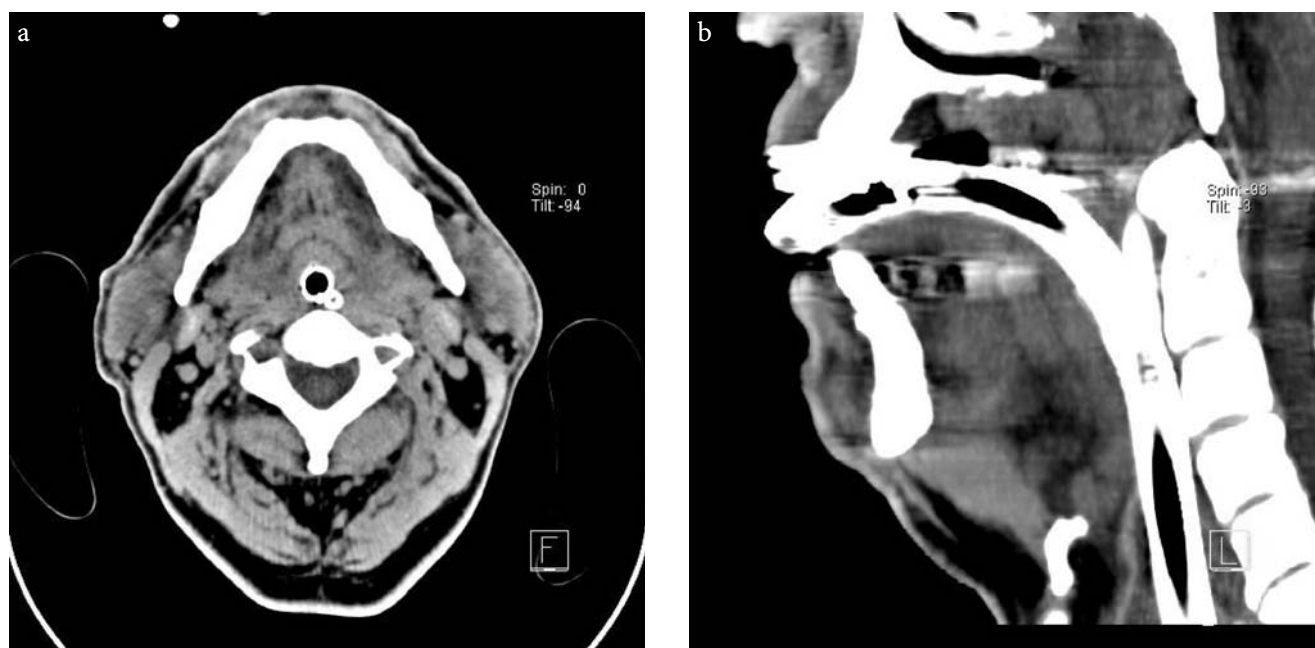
(a) transaxial CT at the level of the base of the tongue shows diffuse swelling of the mouth floor, base of the tongue and oropharynx. Hyperdense areas or anatomical distortion indicating hemorrhage were absent. Note the minimal space for the endotracheal tube. (b) Sagittal midline 2D multiplanar reconstruction of multislice CT scan shows diffuse swelling of the tongue up to the epiglottic level
